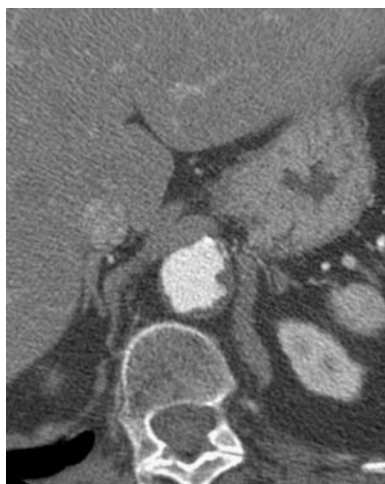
Axial contrast-enhanced CT image of atherosclerotic intraluminal thrombus in a different patient demonstrates the more typical jagged appearance.
